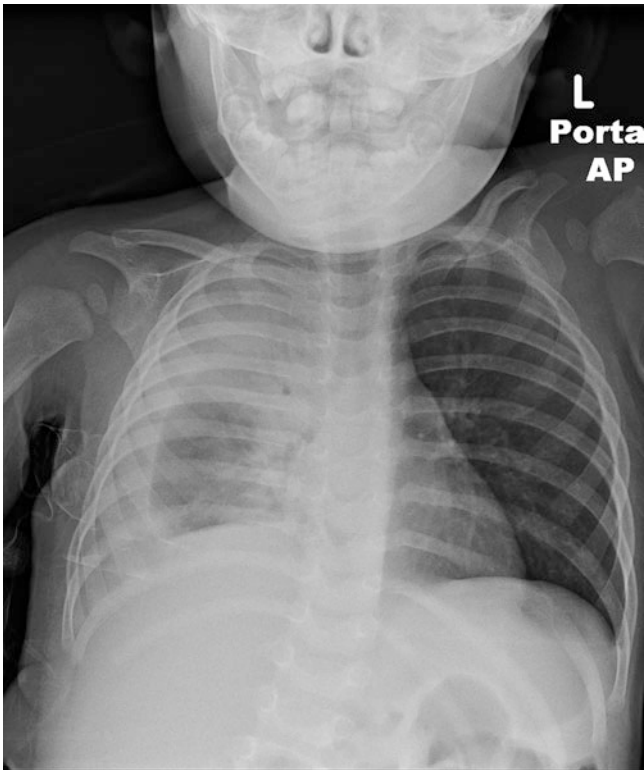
A PA chest radiograph demonstrating a right-sided empyema with incomplete expansion of the lung
